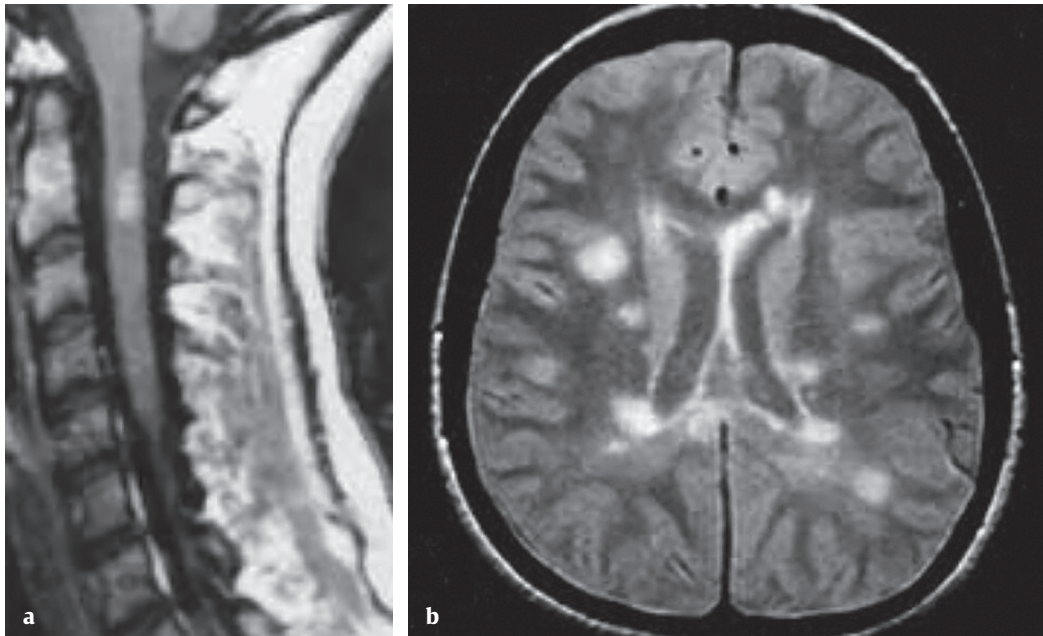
Cervical and brain MRI showing some features of multiple sclerosis (MS). Typical MS plaque in the cervical spinal cord (a). Normally, it is accompanied with multiple plaques in the brain (b).
